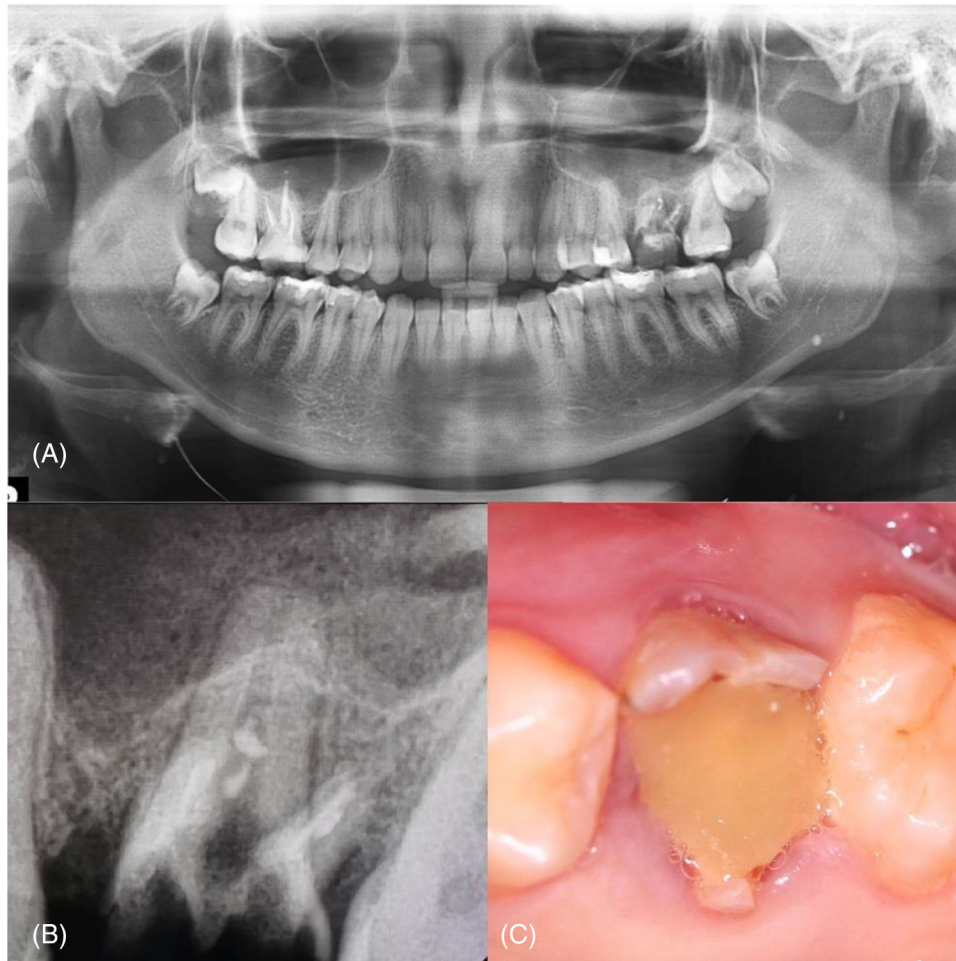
A 16-year-old female patient underwent a clinical and radiographic examination, which revealed an extensively decayed tooth, #14, that was beyond restoration. The examination included the following: (A) A panoramic radiograph demonstrated the condition of the teeth, the level of the bone, and the developing third molars. (B) A periapical radiograph showed an unrestorable badly decayed first permanent molar near the maxillary sinus. (C) A clinical photo depicted the condition of the crown and the supporting tissues.
